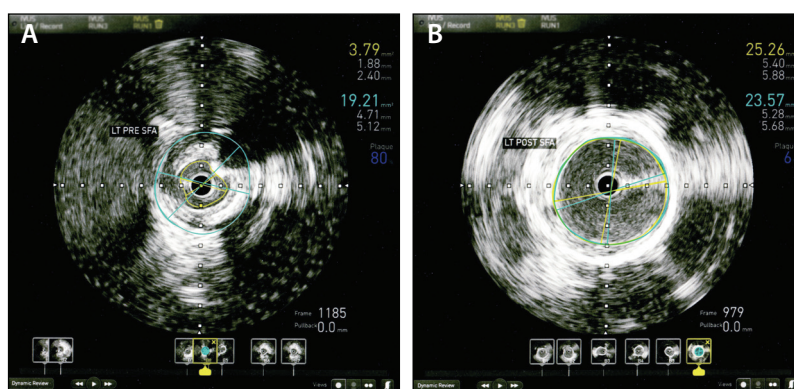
Intravascular ultrasound images before (A) and after (B) treatment. The smooth, clean lumen had a cross-sectional area diameter increase from 4 mm² to 25 mm² and a stenosis percentage decrease from 80% to 6%.
